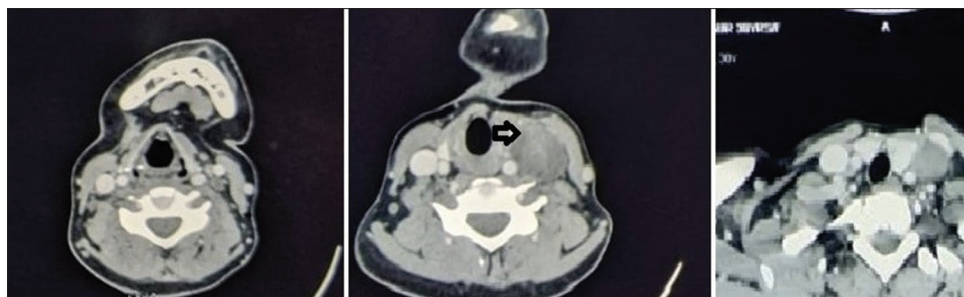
Contrast-enhanced computed tomography showing well-defined mass with peripheral vascularity in the left parapharyngeal space separating common carotid artery and internal jugular vein (IJV) with an impression of compression or involvement of IJV
